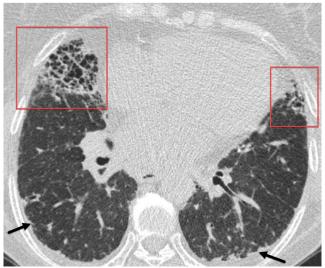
A 53-year-old female patient with a diagnosis of rheumatoid arthritis. Chest CT image shows interlobular septal thickening and honeycomb cyst in both peripheral lung areas (red rectangles). Also, bilateral subpleural reticulations are seen in both posterior-basal segments (arrows).
